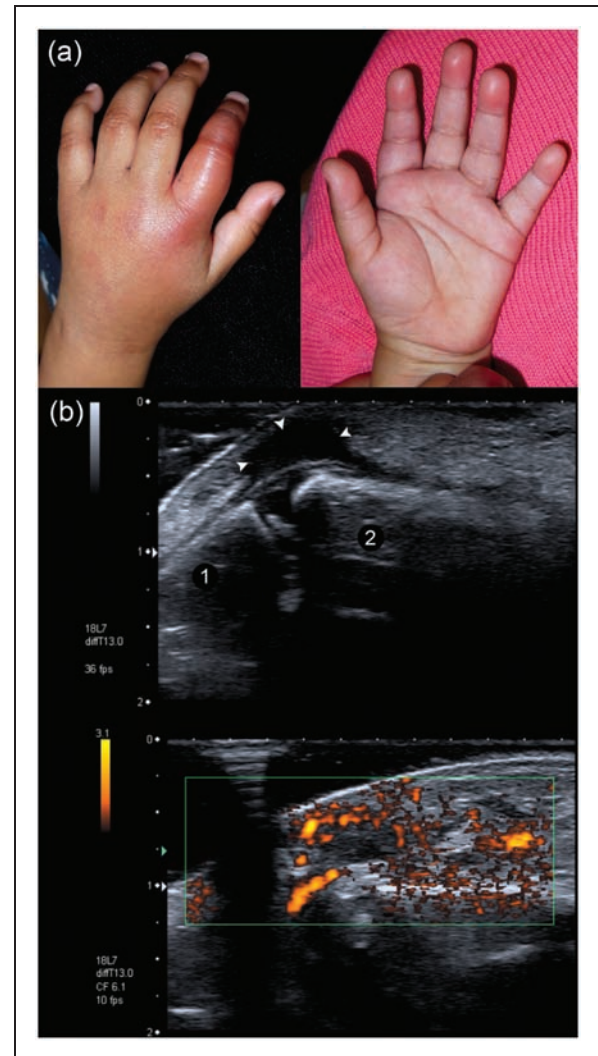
(A) Fusiform swelling and erythema over the left index finger and hand in case 7. The palmar surface is intact. (B) Ultrasound demonstrated subcutaneous fluid collection over the metacarpophalangeal joint of the left index finger (arrowheads, top) and extensor tendons hyperemia at colour Doppler (bottom). 1: second proximal phalanx; 2: second metacarpal bone.
